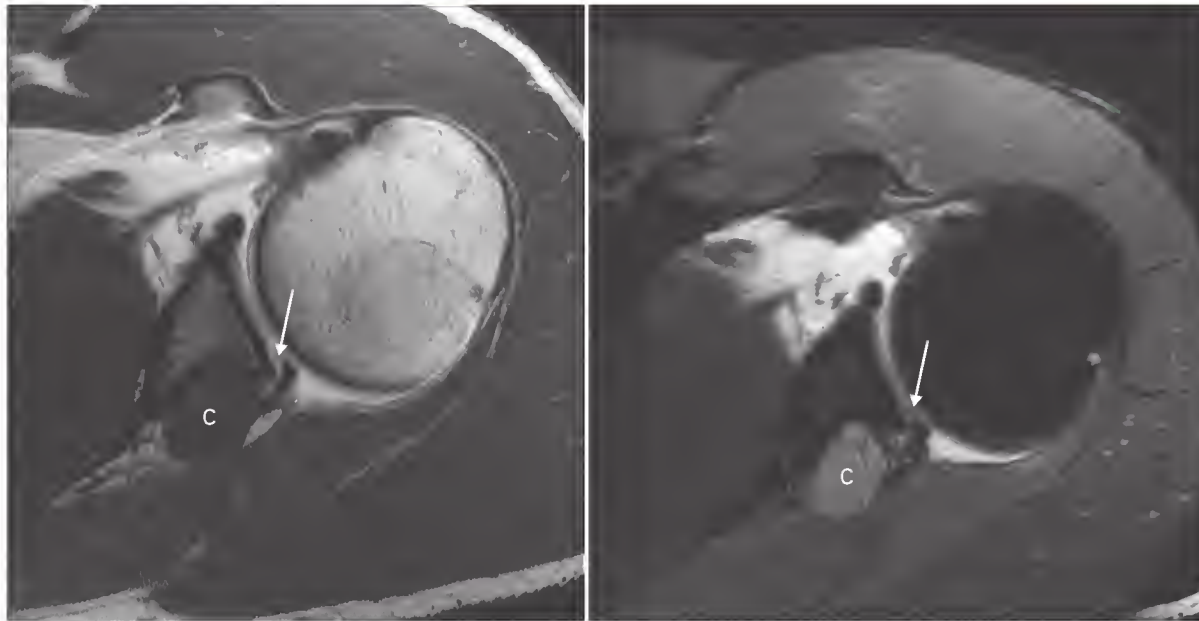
Magnetic resonance image showing a ganglion cyst (C) arising from a tear in the posterior glenoid labrum (arrows).
